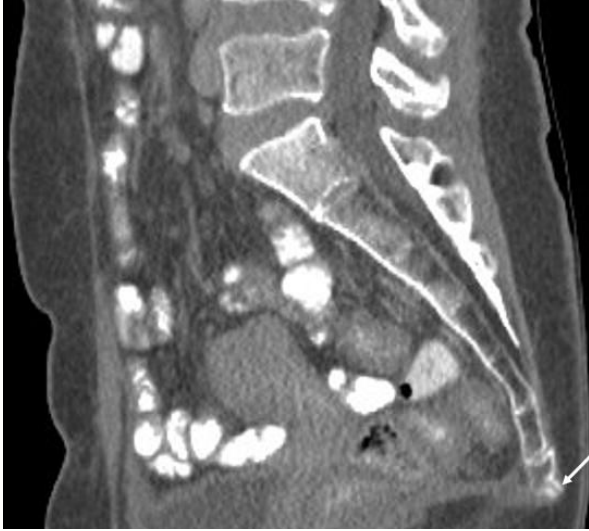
Sagittal CT image of the coccyx demonstrating a mildly posteriorly oriented fragment at the distal coccygeal segment (arrow).
